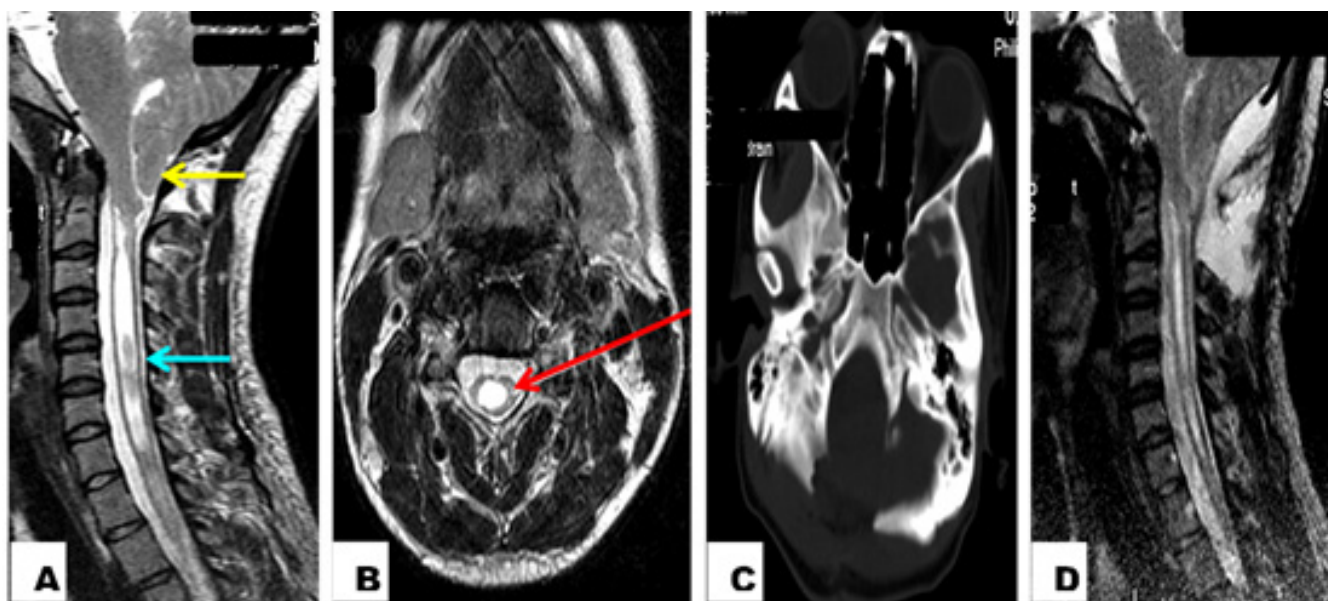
(A-D): Adult female diagnosed with CM type-I and underwent decompression plus duraplasty in our neurosurgery department. A: Preoperative T2 sagittal MRI showing cerebellar tonsillar herniation through foramen magnum (yellow arrow) and central spinal canal dilatation corresponding to syringomyelia (blue arrow); B: Preoperative T2 axial MRI showing tonsillar herniation through foramen magnum (red arrow); C: Postoperative computed tomography CT (bone window) showing the suboccipital craniectomy; D: Postoperative T2 sagittal MRI showing slight regression of the syrinx cavity.
